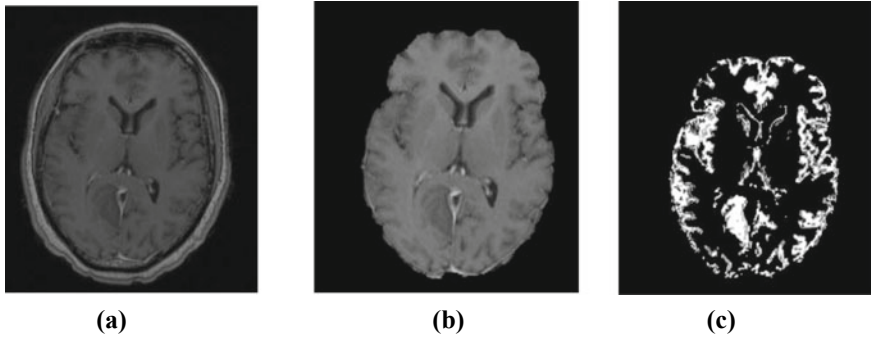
Processing of radiology images: slice of T2-weighted MRI image. a Bias corrected image. b Skull Stripping using BET. c Partial volume map of the fourth class obtained using FAST algorithm
